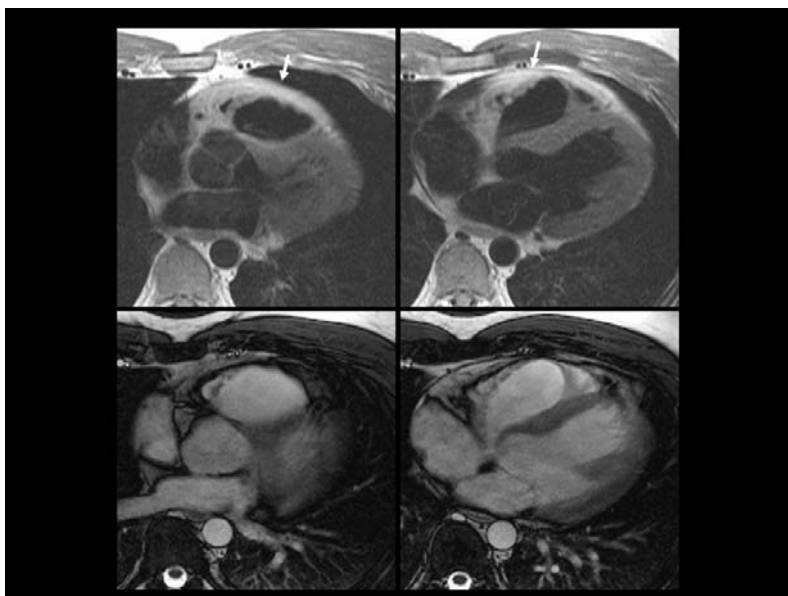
Arrhythmogenic right ventricular dysplasia (MRI). Adjacent oblique-transaxial 'dark blood' images (*upper images*) and corresponding images from cine 'bright blood' image loops (*lower images*) are shown. The former reveal bright fatty tissue replacing the musculature of the anterior surface of the lower outflow tract and upper body of the right ventricle; the latter demonstrate systolic dysfunction in the same areas
